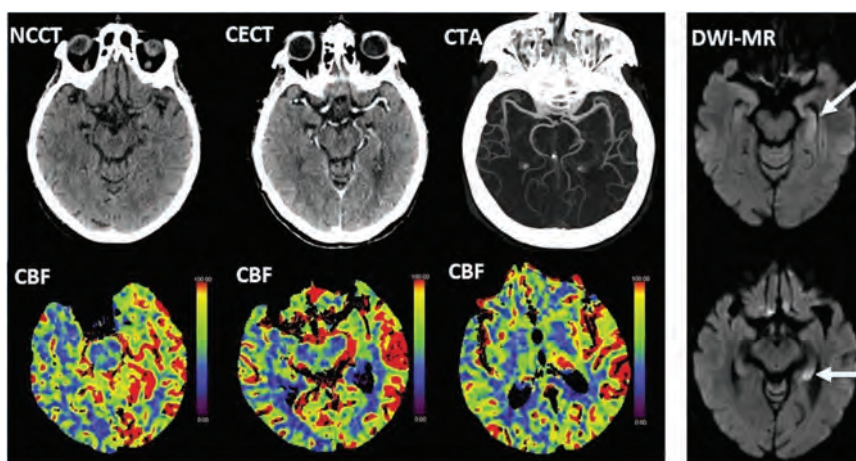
Left panel: elevated CBF consistent with hyperperfusion involving the left temporo-occipito-parietal cortex and left pulvinar in a 77-year-old woman with acute right-sided motor impairment, right hemineglect, aphasia, and conjugate eye deviation to the right. Note normal findings on NCCT, CECT, and CTA. Right panel: Diffusion MR imaging excludes ischemia and demonstrates seizure changes (arrows) in the left hippocampus.
